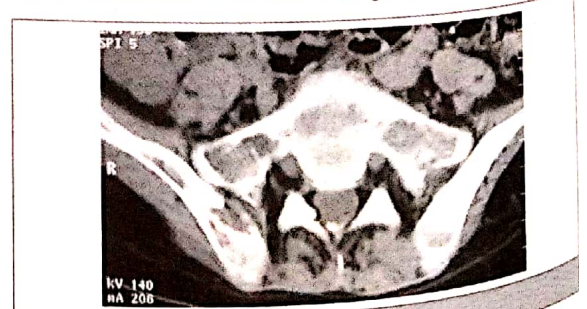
Sacroiliac tuberculosis (CT)
